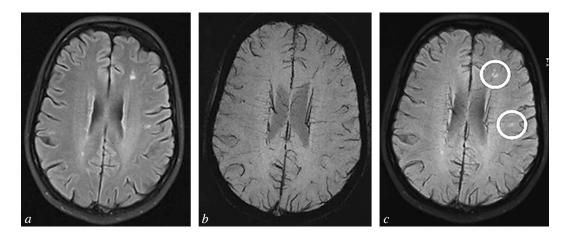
Brain MRI scan from a patient with MS in FLAIR (a) and SWI (b) modes and the two combined (c). Scans show perivenular location of demyelination plaques in the FLAIR\* image (venocentric pattern).
